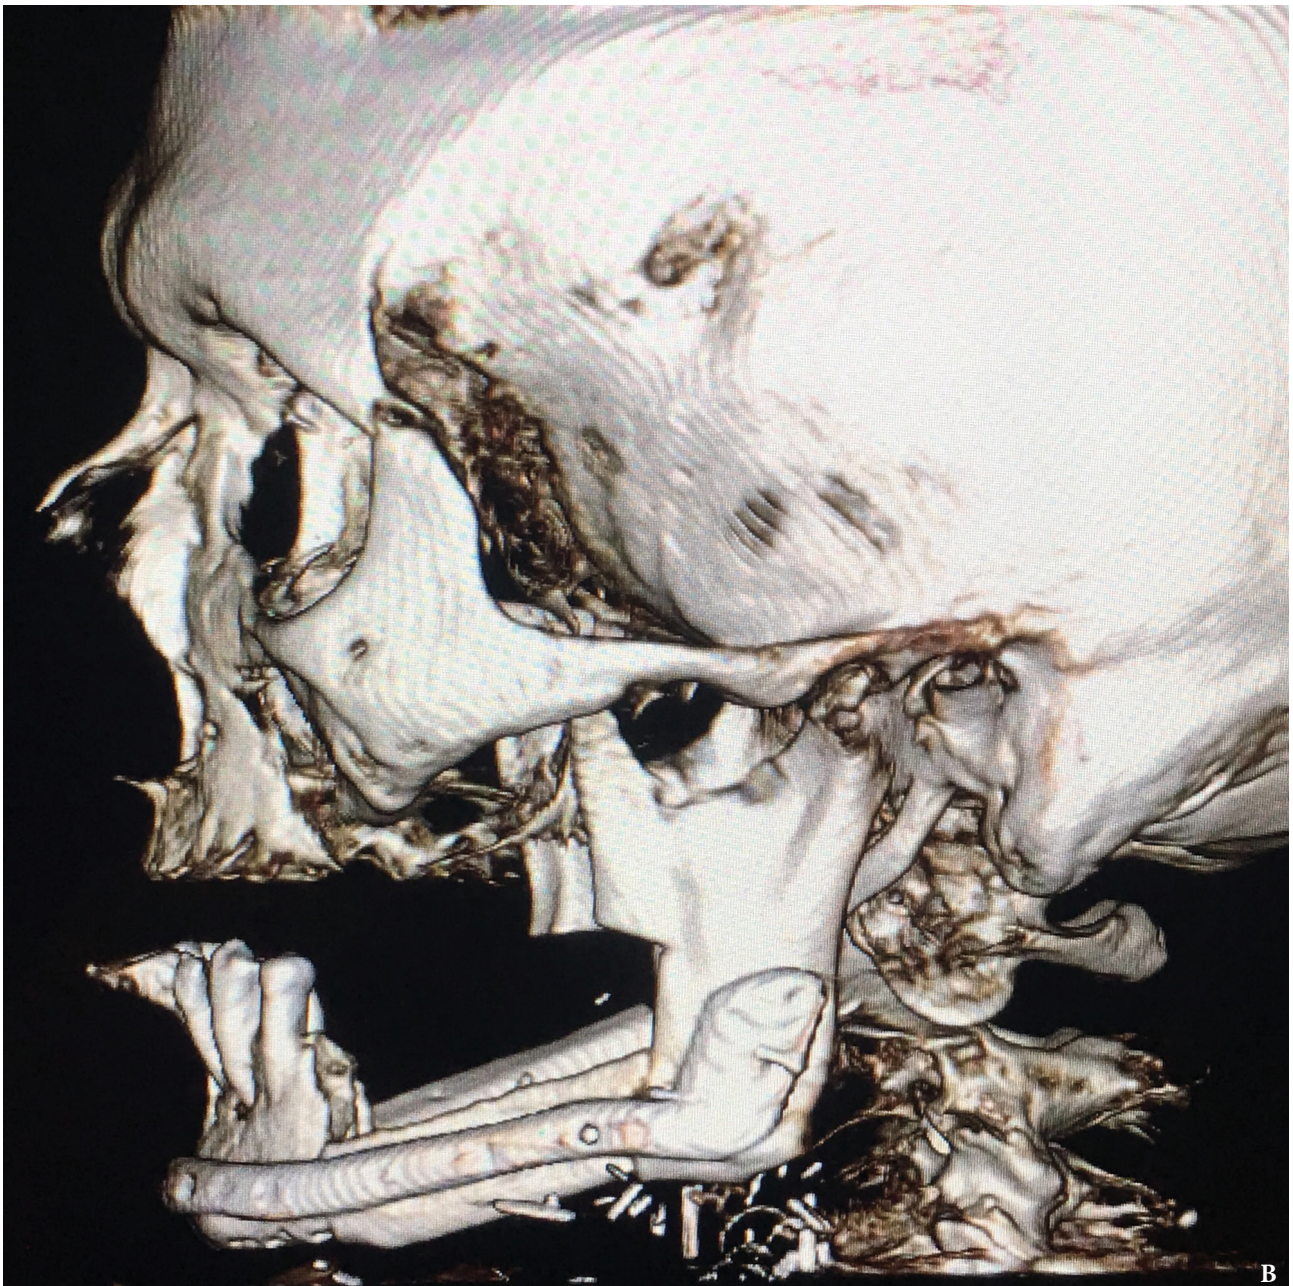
(cont'd). Postoperative control of reconstruction with 3D-CT: Left lateral view (B). (Fig 7 continued on next page.)
